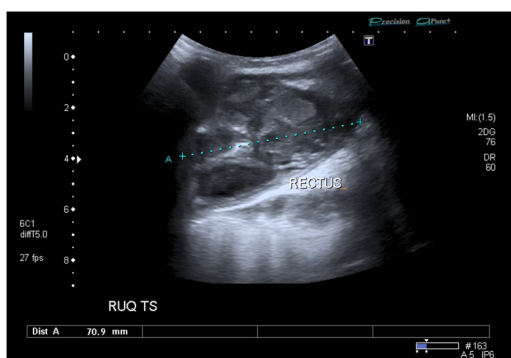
Ultrasound scan transverse view of right upper quadrant anterior abdominal mass.
